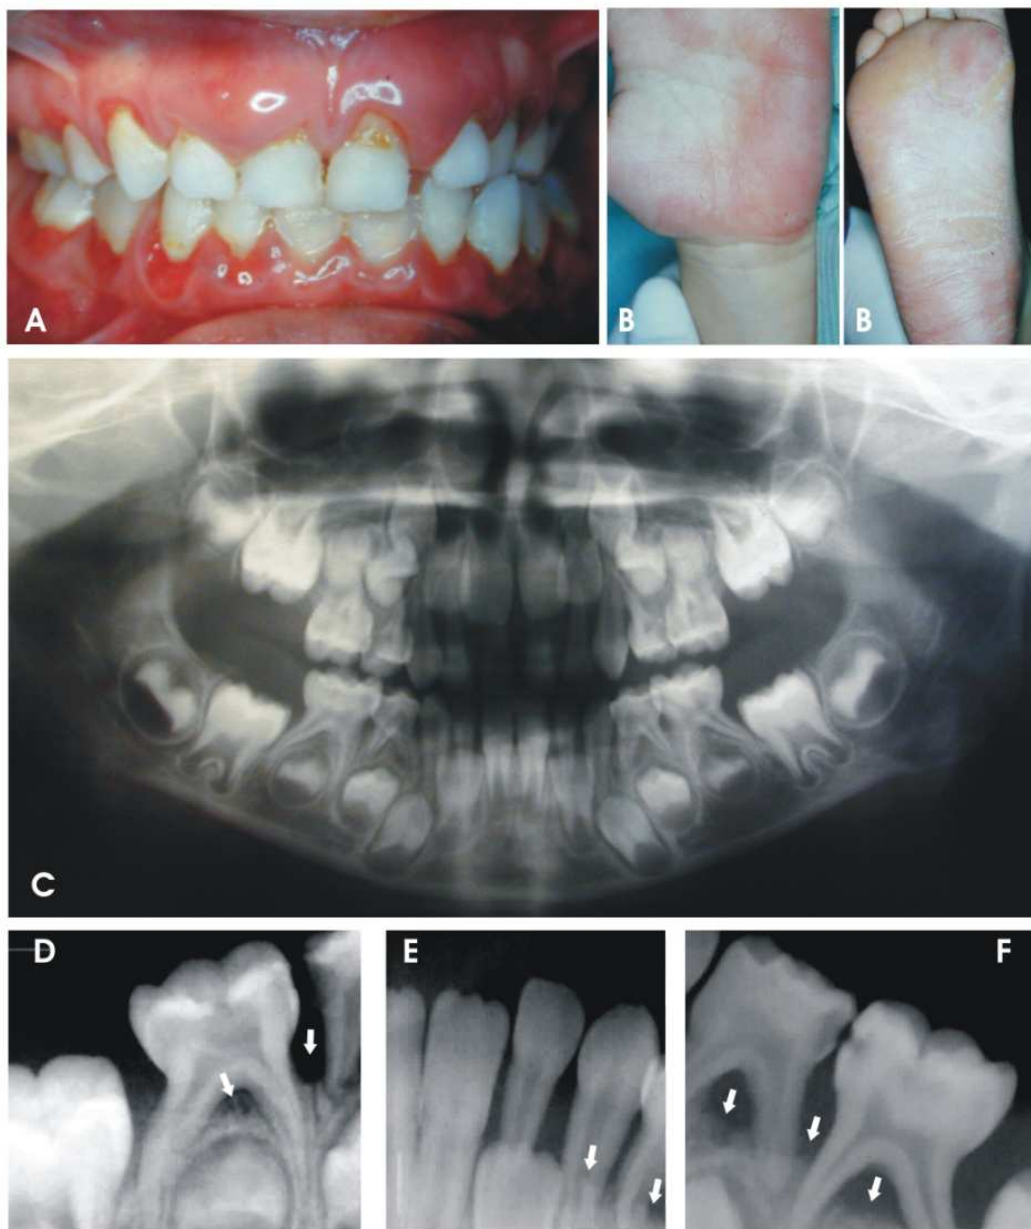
Papillon-Lefèvre syndrome in a 6-year old child. A. Clinical manifestation of the extended periodontal inflammation affecting the primary dentition. B. Hyperkeratotic palmo-plantar skin lesions C-F. Radiographs showing the severe bone loss (arrows) around the teeth. Cultures of samples from the periodontal pockets revealed the rich presence (up to 70% of the total sample flora) of *A. actinomycetemcomitans*. (unpublished data of author SK).
